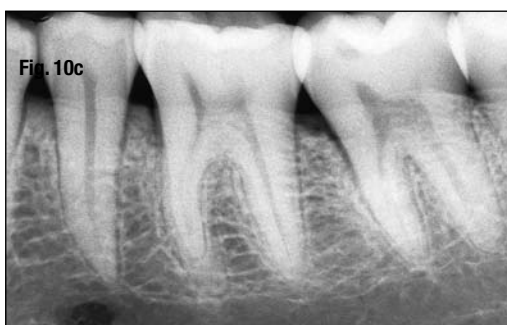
10c_A third radiograph with increased corono-apical angulation confirms once again that the structure is more buccal with respect to the apex of the second premolar.
